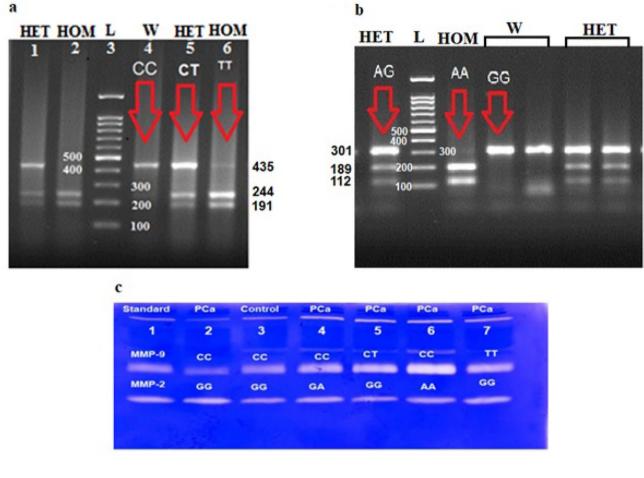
Agarose gel electrophoresis (1.5%) pattern of MMP-9, C1562T digested PCR products with SphI enzyme. From left to right lanes 2 and 6 indicate HOM: homozygous mutant (TT: 244, 191 bp), lanes 1 and 5 demonstrate HET: heterozygous mutant (CT: 435, 244, 191 bp), lanes 4 indicates W: homozygous wild-type (CC: 435 bp) and lane 3 shows L: 1000 bp ladder (a). Agarose gel electrophoresis (1.5%) pattern of MMP-2, G1575A digested PCR products with pagI enzyme. From left to right lanes 1, 6 and 7 demonstrate HET: heterozygous mutant (AG: 301, 189, 112 bp), lane 2 shows L: 1000 bp ladder, lane 3 indicates HOM: homozygous mutant (AA: 189, 112 bp), lanes 4 and 5 indicate W: homozygous wild-type (GG:
